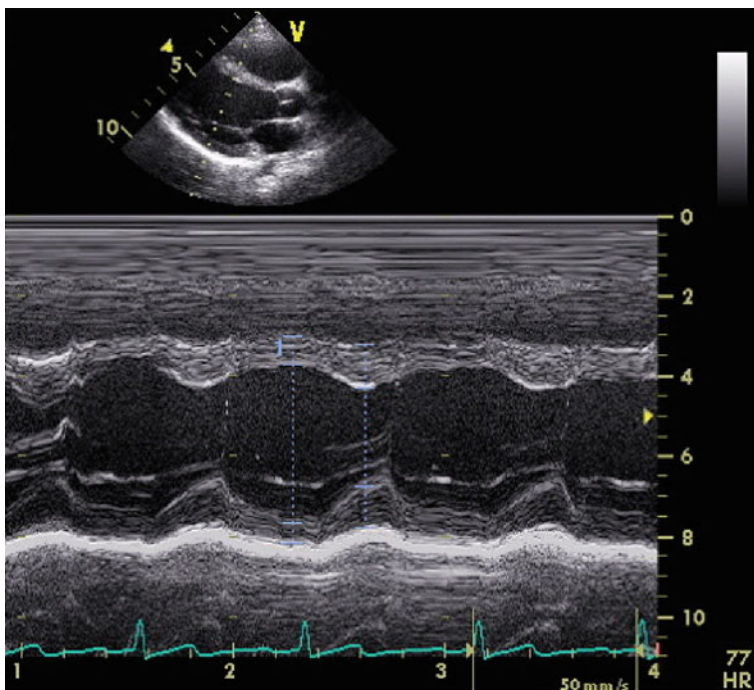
M-mode echocardiogram acquired over multiple cardiac cycles. The *dashed lines* estimate systolic and diastolic parameters to derive functional indices such as stroke volume and ejection fraction
